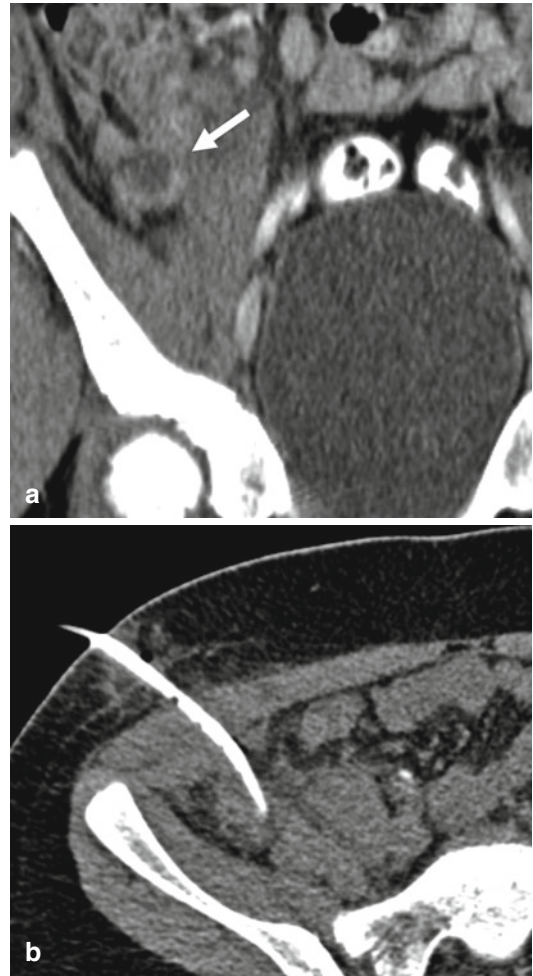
Preinterventional computed tomography (CT; 100 kVp, 75 mA s_{eff}) in a 12-year-old boy after appendectomy. Coronal multiplanar reformation demonstrates an abscess in the right lower abdomen (a; arrow). After successful placement of an 8.5-F drainage catheter using the trocar technique (b), the abscess completely resolved within 8 days, proving the success of the interventional procedure
